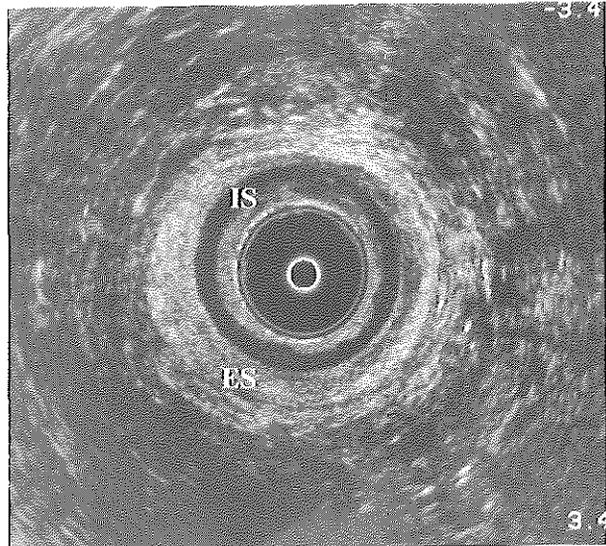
Endoanal sonography showing a normal external (ES) and internal sphincter (IS). Compare with Fig.1.
